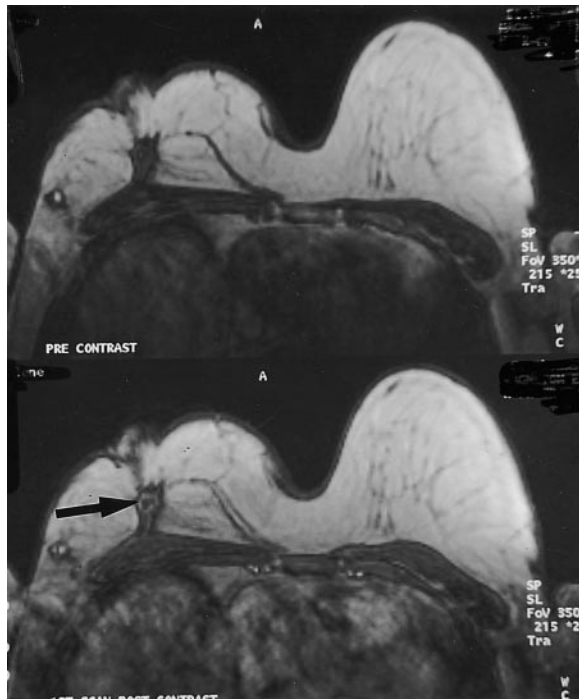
Pre-contrast (upper) and post-contrast (lower) MRI after breast conservation. Rim enhancement (arrow) suggesting malignancy. On biopsy, a granulomatous reaction to suture material is seen.
